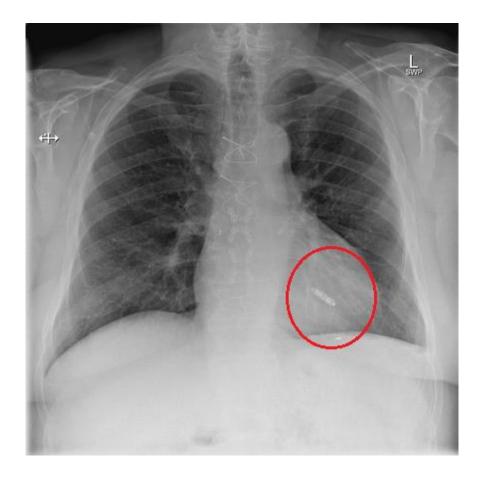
Chest x-ray showing a leadless pacemaker (marked in red circle) implanted in a patient.
